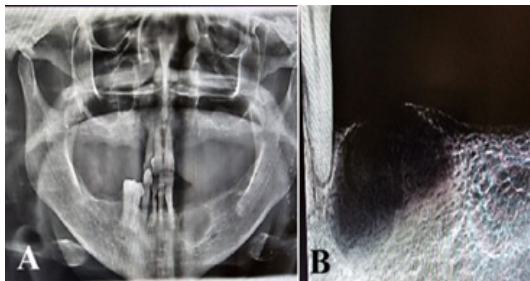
A: Panoramic X-ray; B: Periapical X-ray
